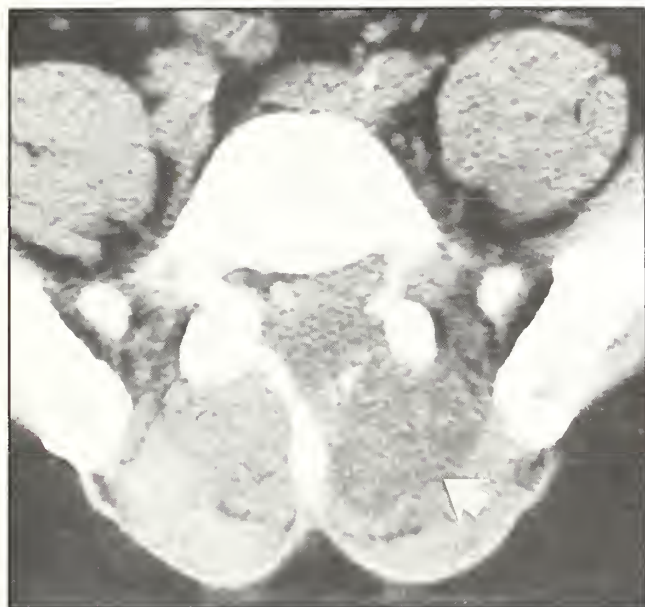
Lumbar CT showing destruction of the posterior elements of L-5 (arrow).
